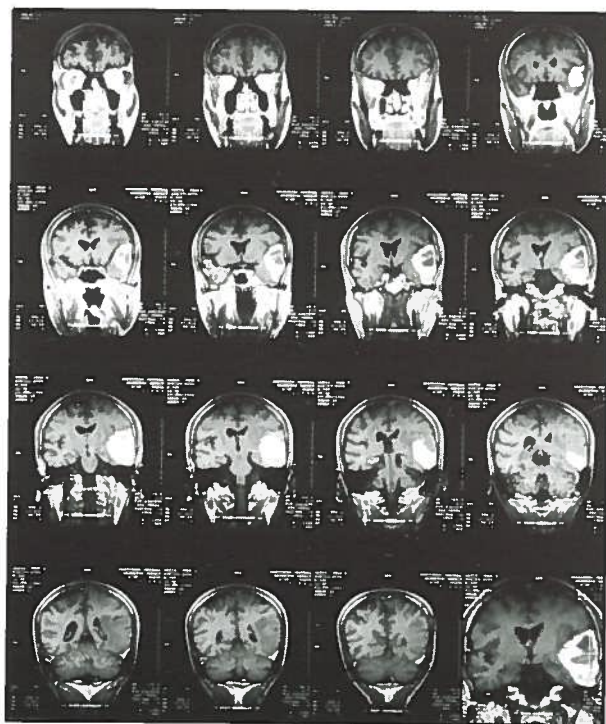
Head MRI showing left parietal hemispheric infarction with associated hemorrhage.
